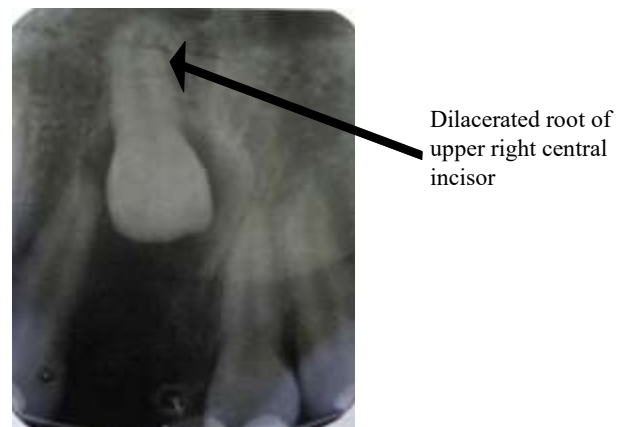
Periapical radiograph showing Unerupted dilacerated upper right central incisors post extraction of the multiple odontomes and retained primary upper right incisors
